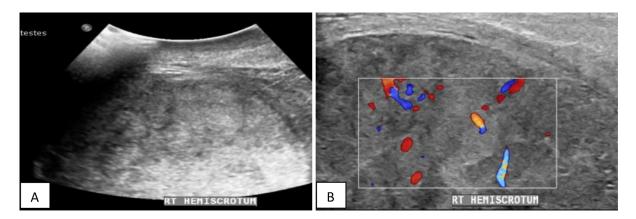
US doppler testis: herniated content from right inguinal canal down to the right hemi-scrotum (A), with minimal flow on doppler study (B).
